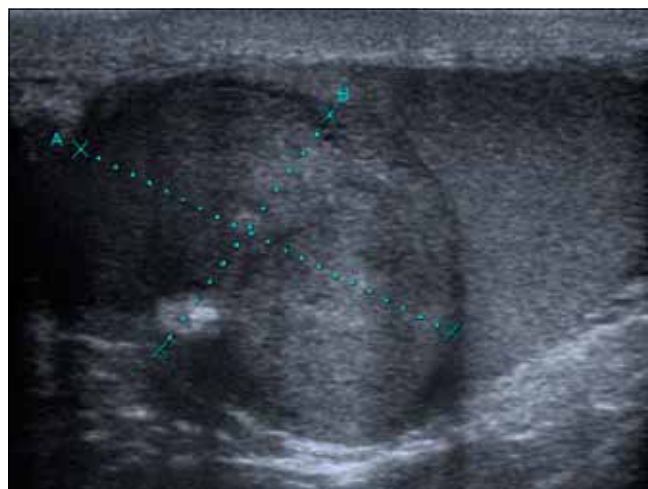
Ultrasound image of the right testis showing mixed echogenic mass in upper pole in keeping with testicular tumour
